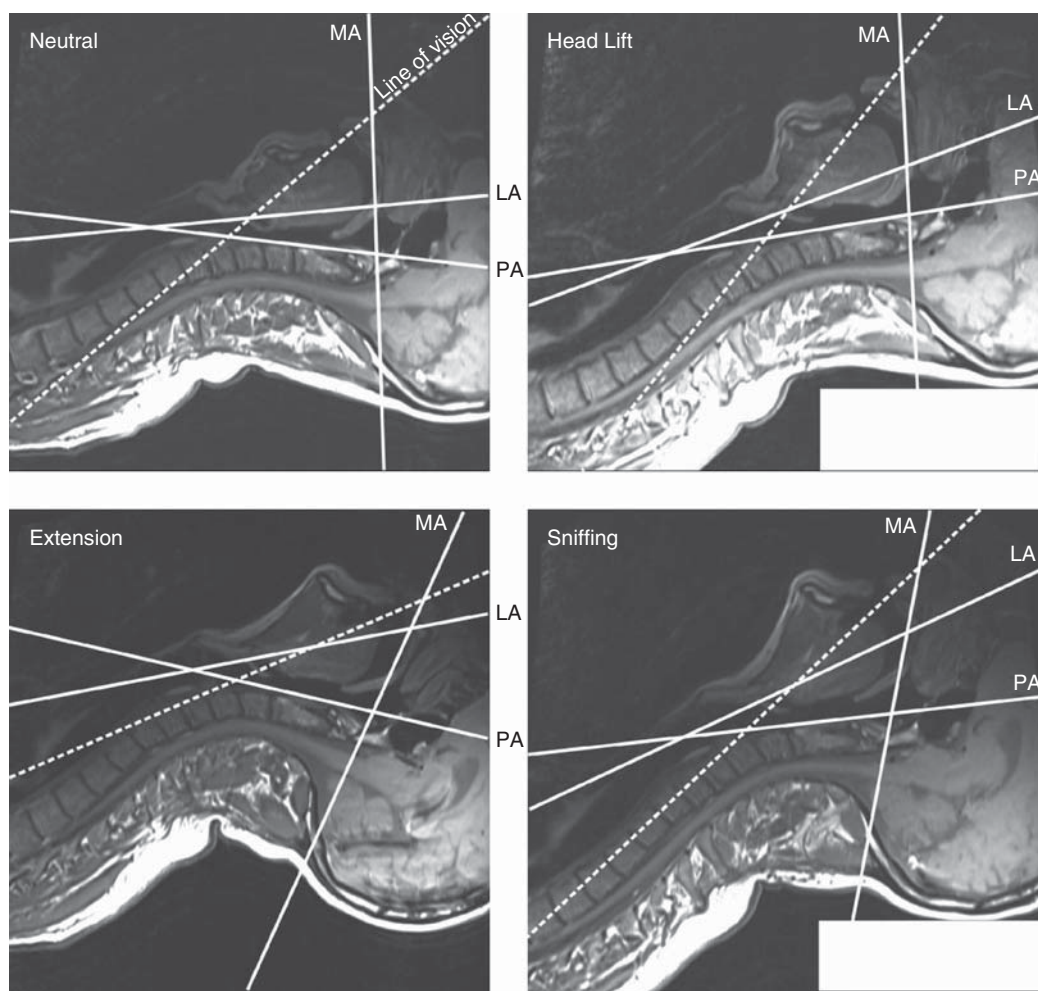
The MRI scans of one of the authors (K.B.G.) in different head and neck positions—neutral (no head elevation and vertical gaze), head lift (neck flexion to 35° and vertical gaze), head extension (no head elevation and face plane extension), and sniffing (flexion of the lower neck to 35° and extension of the face plane to 15°). The following axes are superimposed on the MRI scans. Mouth axis (MA) is defined as a straight line drawn parallel to the hard palate; pharyngeal axis (PA) is defined as a line passing through the anterior edge of the atlas and of the second cervical vertebra; laryngeal axis (LA) is defined as a straight line passing through the centres of the inferior (cricoid cartilage) and superior (base of epiglottis) orifices. The line of vision is defined as a straight line passing through the inferior extremity of the superior incisors and the posterior extremity of the superior portion of the cricoid cartilage as shown by the dotted line. The descriptions for the different axes by Adnet and colleagues⁴ were used to govern their positions on the scans.
